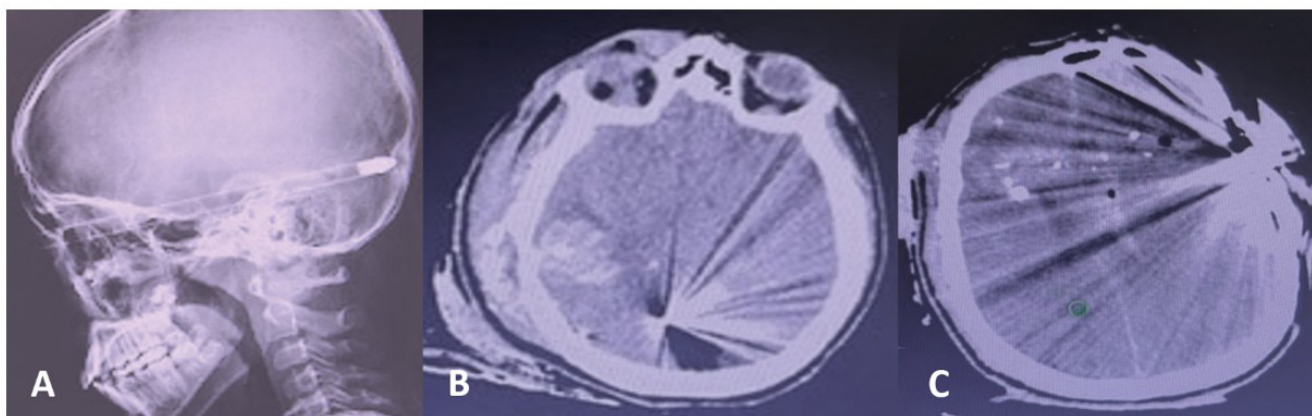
(A) Skull lateral X-ray with FAP; (B-C) CT scans with penetrating and transfixing FAP.
